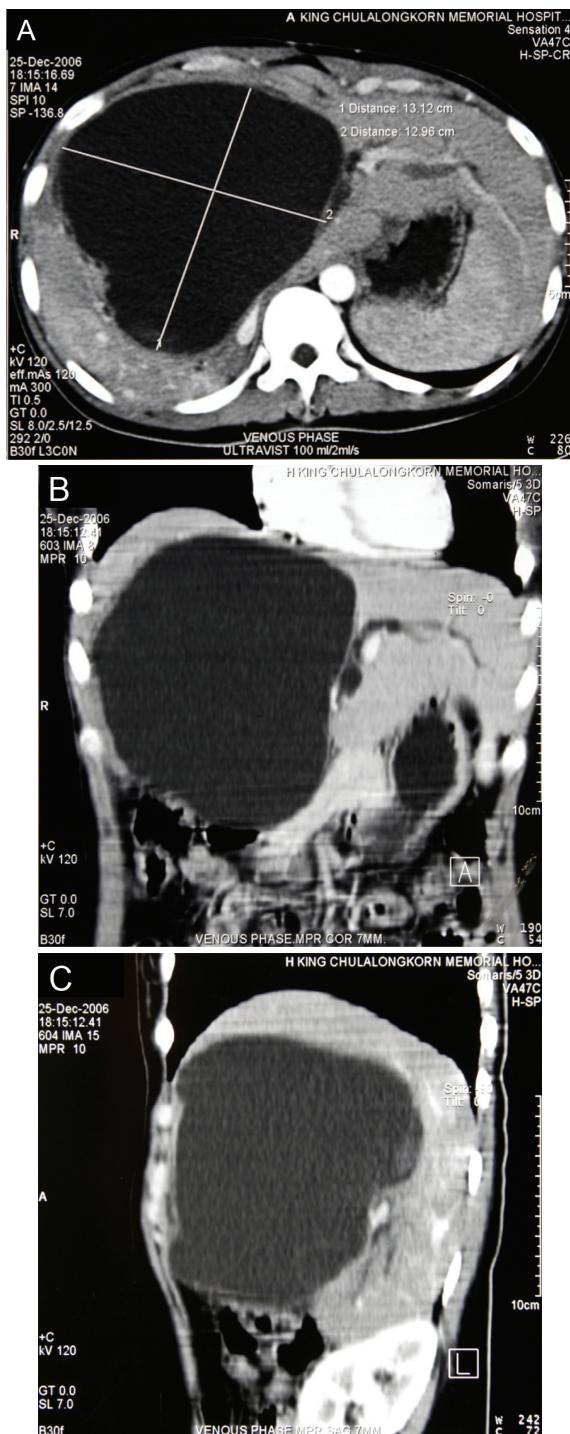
CT scan of the abdomen on 25th December 2006, 20 months after re-operation (the second operation) and 50-60% cyst wall excision. Recurrent large cystic lesion of the liver (13.5 x 12.2 x 15.2 in size) was demonstrated. A) Horizontal plane, B) Frontal plane, C) Sagittal plane
